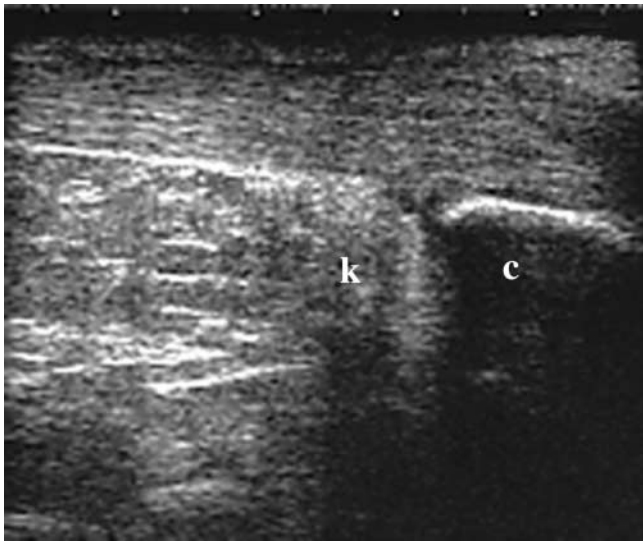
Longitudinal scan of Achilles peritendinitis in a 28-year-old male amateur tennis player who had experienced achillodynia upon normal gait for 20 days. The distal third of the tendon is slightly thickened (7.8 mm instead of the normal 5.7 mm), homogeneous, with the posterior of the peritendineum sonographically blurred. *k*, Karger's triangle; *c*, heel
